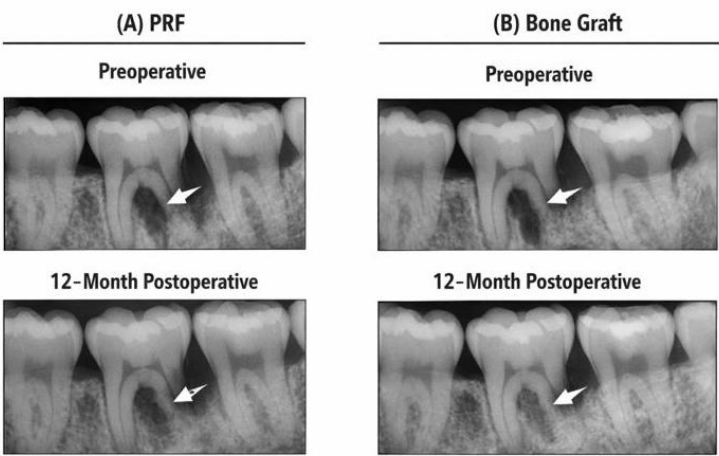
Preoperative radiographs showing intrabony periodontal defects and corresponding 12-month postoperative radiographs demonstrating bone fill following treatment with (A) platelet-rich fibrin (PRF) and (B) bone graft.
